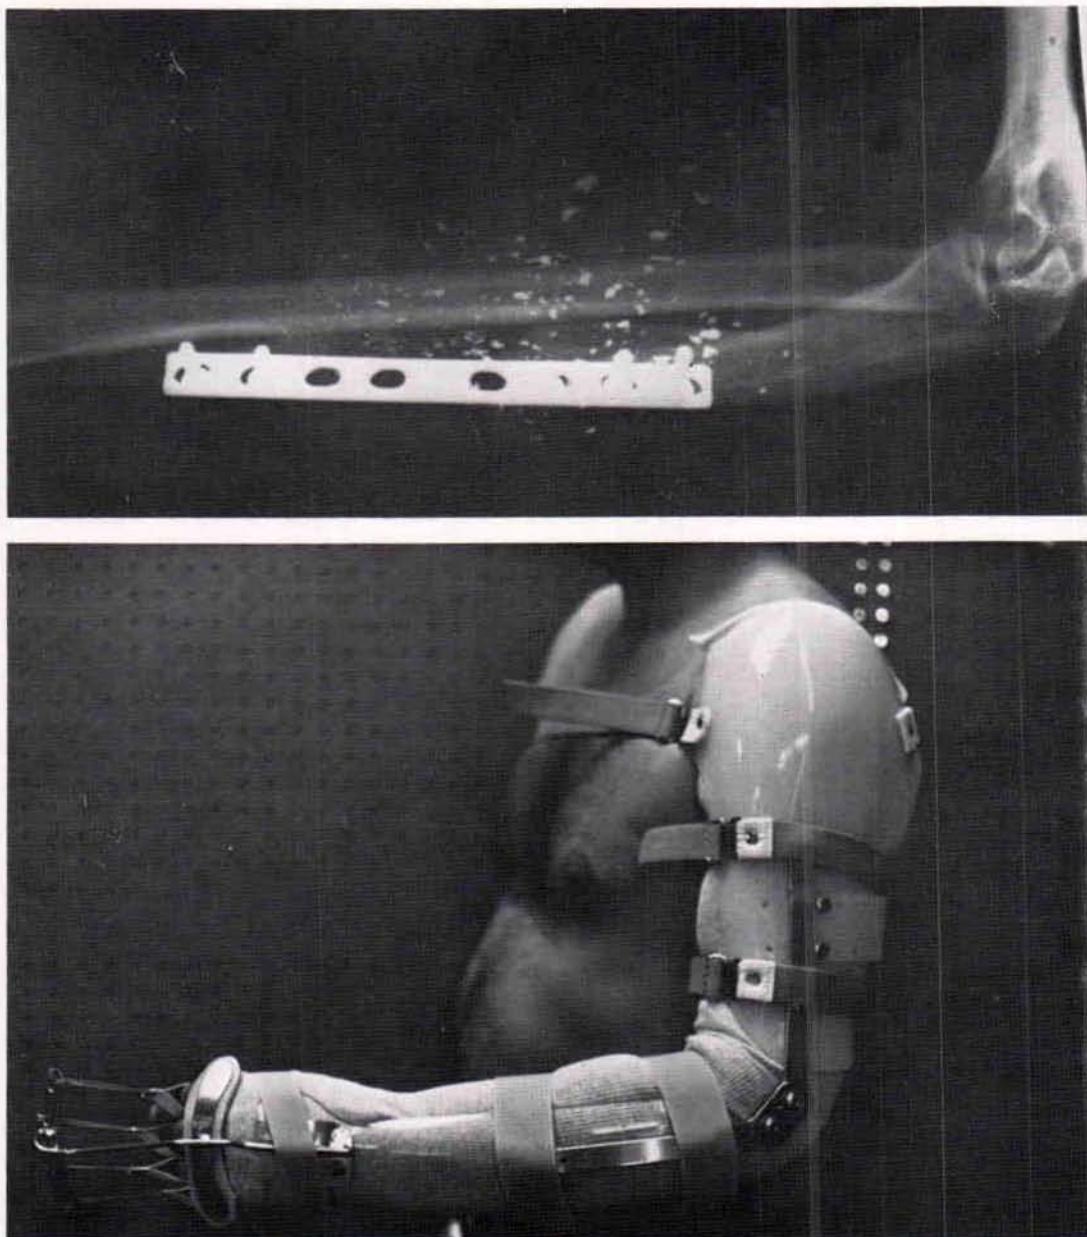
Upper photo: x-ray of forearm of Case IV; lower: lateral view of the orthosis provided Case IV.
